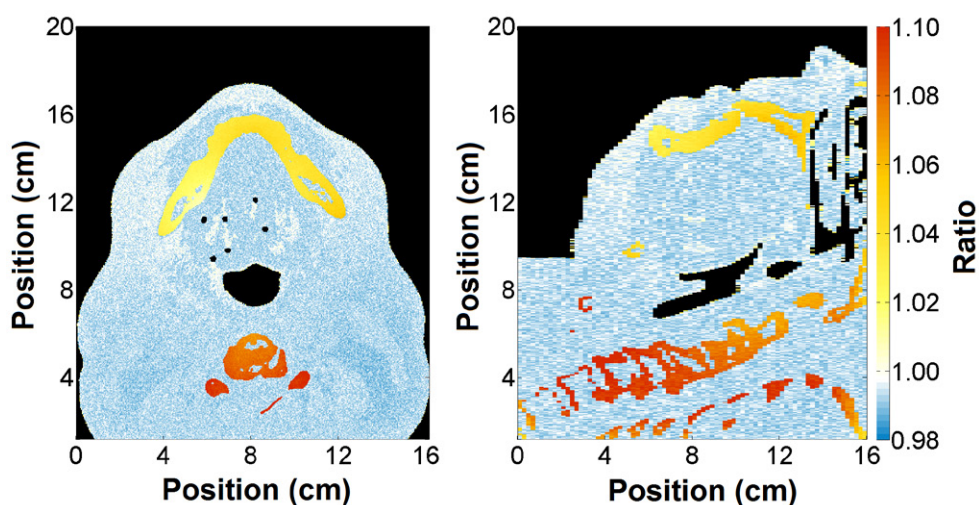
Ratio ($D_{m,m} / D_{w,m}$ (LCT)) obtained using a track length estimator tally. Uncertainty $<1\%$ for all points inside of the CT volume (Type A $\pm 1\sigma$). Regions with air were excluded.
